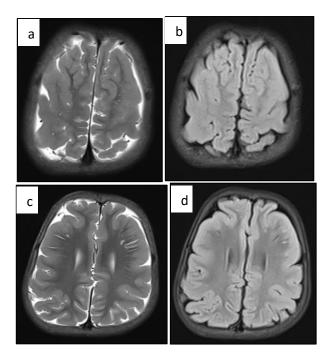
(a-d): T2/FLAIR axial images showed reduction in the number of frontal gyri and marked thickening of frontal cortex with smooth cortical surface suggestive of pachygyria. Few of gyri are abnormally shallow in bilateral frontal location and cortex reaching up to subcortical grey matter in left frontal region likely FCD variant.
